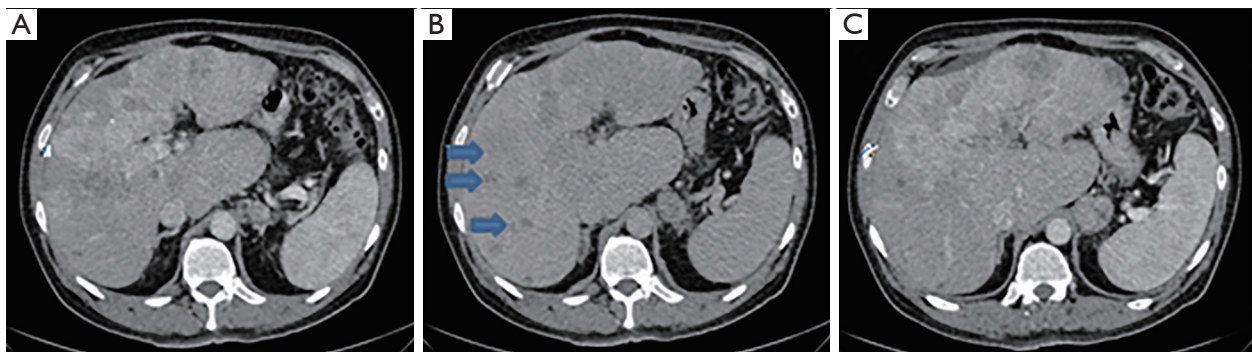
CT scan liver views. Chronic liver disease (liver enlargement and splenomegaly). Several liver lesions with early arterial phase enhancement (A) and rapid washout (B, blue arrows), suspicious for hepatocellular carcinoma. Enlarged gastrohepatic node (C).
